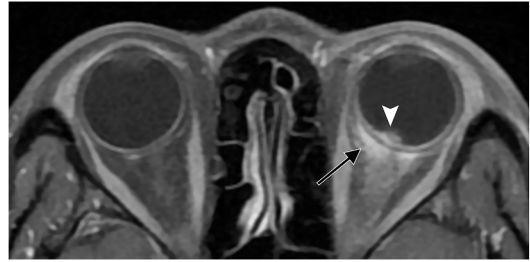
Axial fat-suppressed gadolinium-enhanced T1-weighted MR sequence demonstrating left posterior scleritis (*black arrow*). This is nodular in appearance and can mimic a choroidal tumor (*arrowhead*). Follow-up imaging showed post-treatment resolution.
